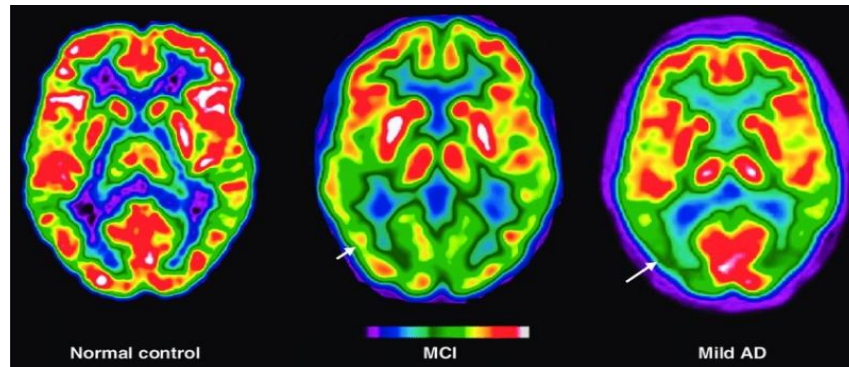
FDG-PET of control, MCI, and mild AD individuals. FDG-PET shows reduced uptake of regional CMRgl in the temporal-parietal cortex (shown as arrows) in MCI and AD patients [8].
